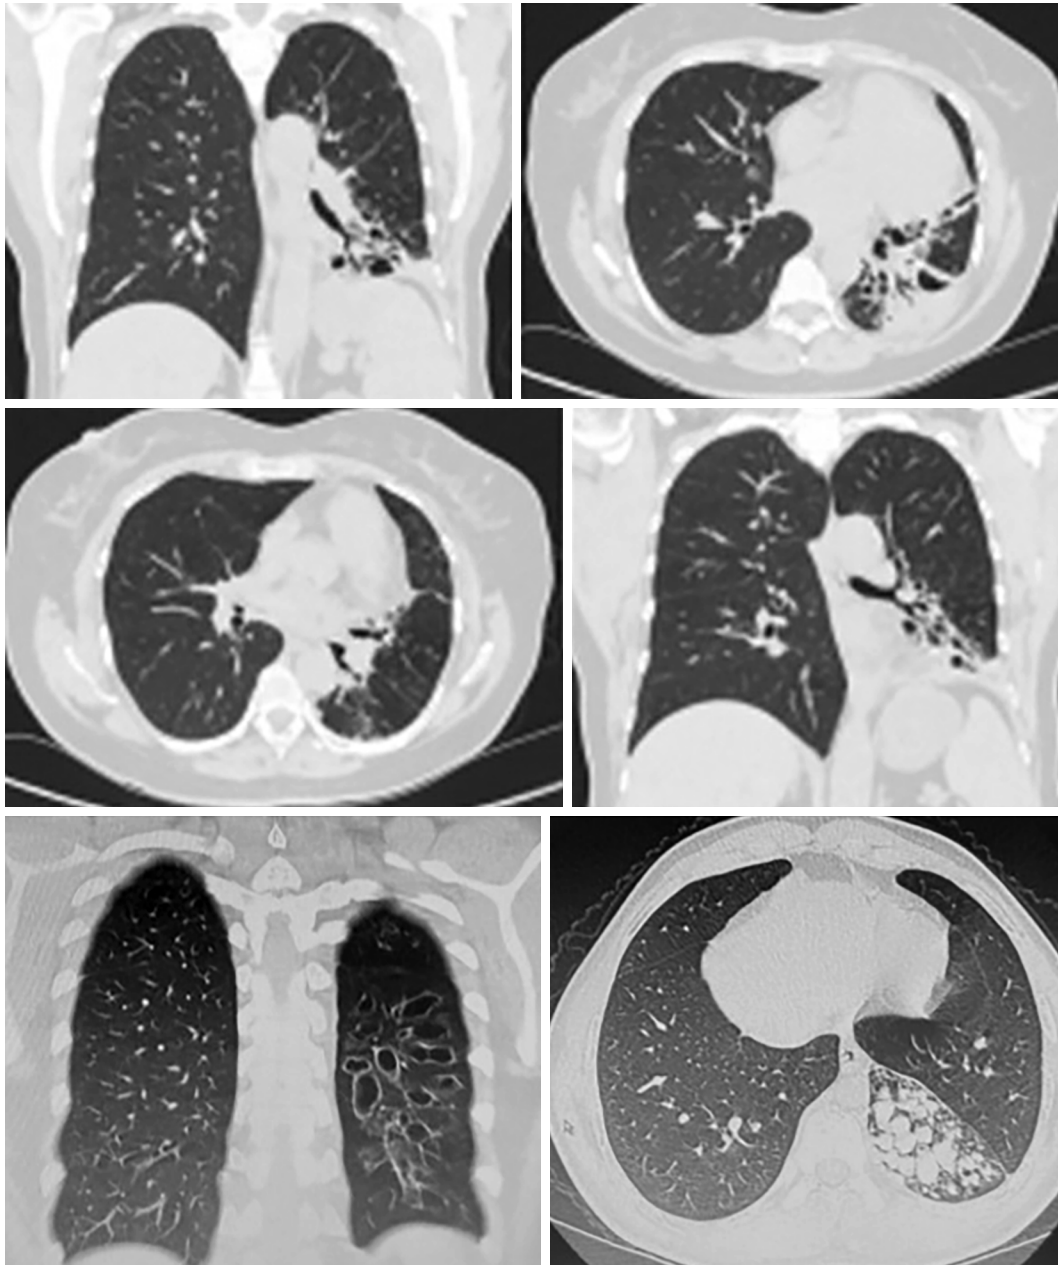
Thorax computed tomography images of bronchiectasis cases.
